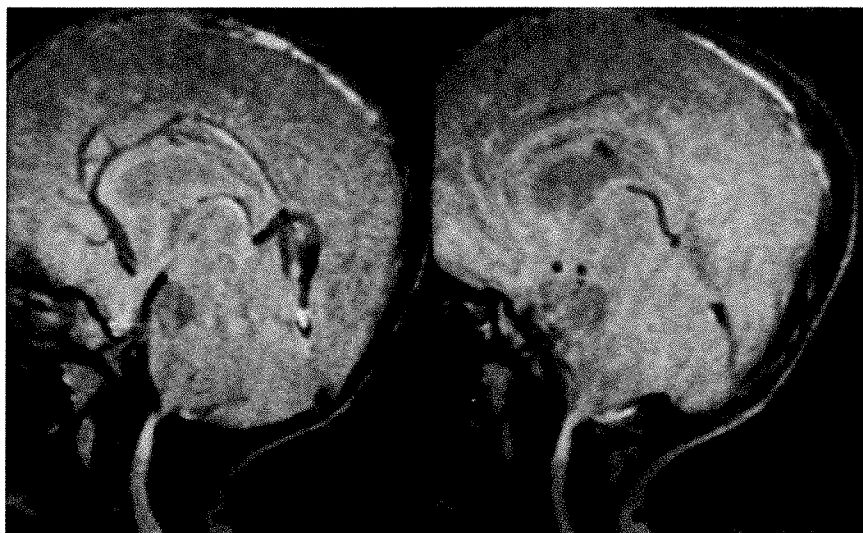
Contiguous 5-mm sagittal T2-weighted MR images (SE 1700/100) in an 11-month-old girl show marked narrowing of subarachnoid space at craniocervical junction and prominence of deep cerebral veins.
